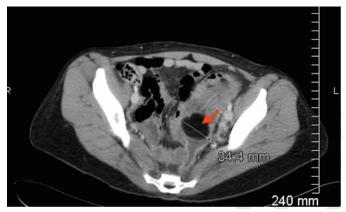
Axial view of abdomen and pelvis computed tomography scan, with contrast, showing intussusception and lipoma with 34.4 mm lipoma indicated.
